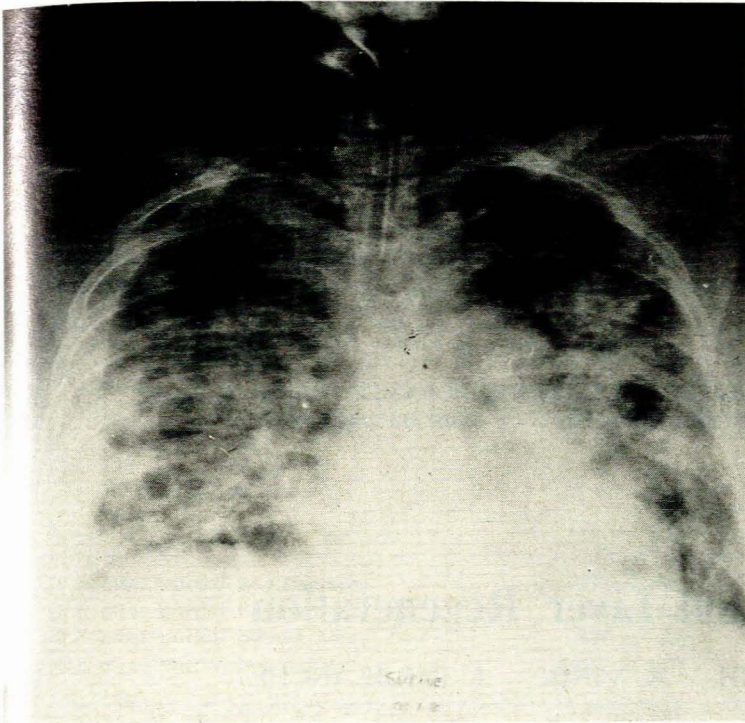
Case 3. Radiographs on admission (top) and discharge (bottom) from Unit. Resolving *Pseudomonas* empyema visible on right side on discharge.
